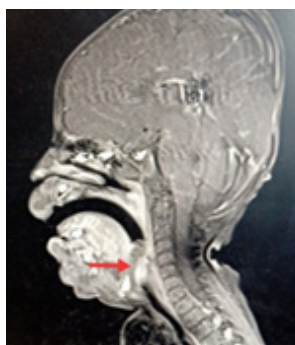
CT-Scan head and neck.
